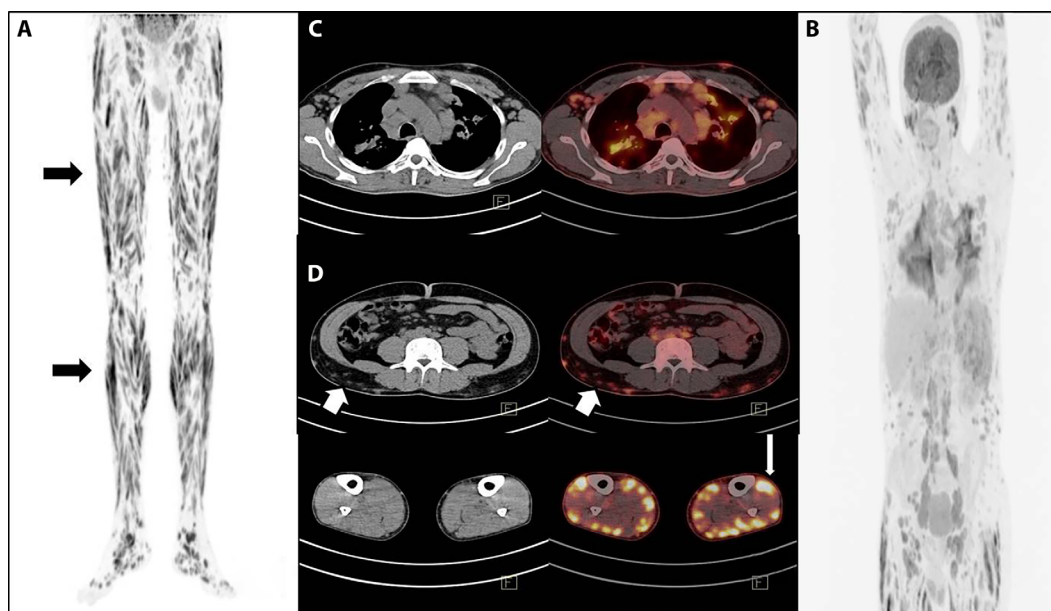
(a) Maximal Intensity Projection (MIP) view of the 18F FDG PET CT scan displaying several regions of linear and patchy fluorodeoxyglucose (FDG) uptake in bilateral lower extremities akin to a tiger's pelage, referred to as "Tiger Man" (black arrow); (b) Furthermore, perihilar consolidative lesions with abnormal FDG uptake in both lungs and hypermetabolism in multiple lymph nodes and spleen are seen; (c) axial CT and fused PET/CT images demonstrate hypermetabolic enlarged lymph nodes in bilateral armpits and mediastinum; (d) Axial CT and fused PET CT images demonstrating multiple focal hypermetabolic lesions in skeletal muscles (white arrow) and multiple hypermetabolic subcutaneous foci (thickened White arrows).
